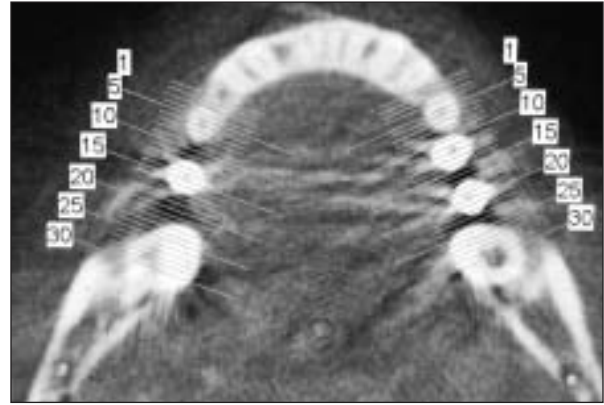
Preoperative CT obtained 1 month before surgery.
